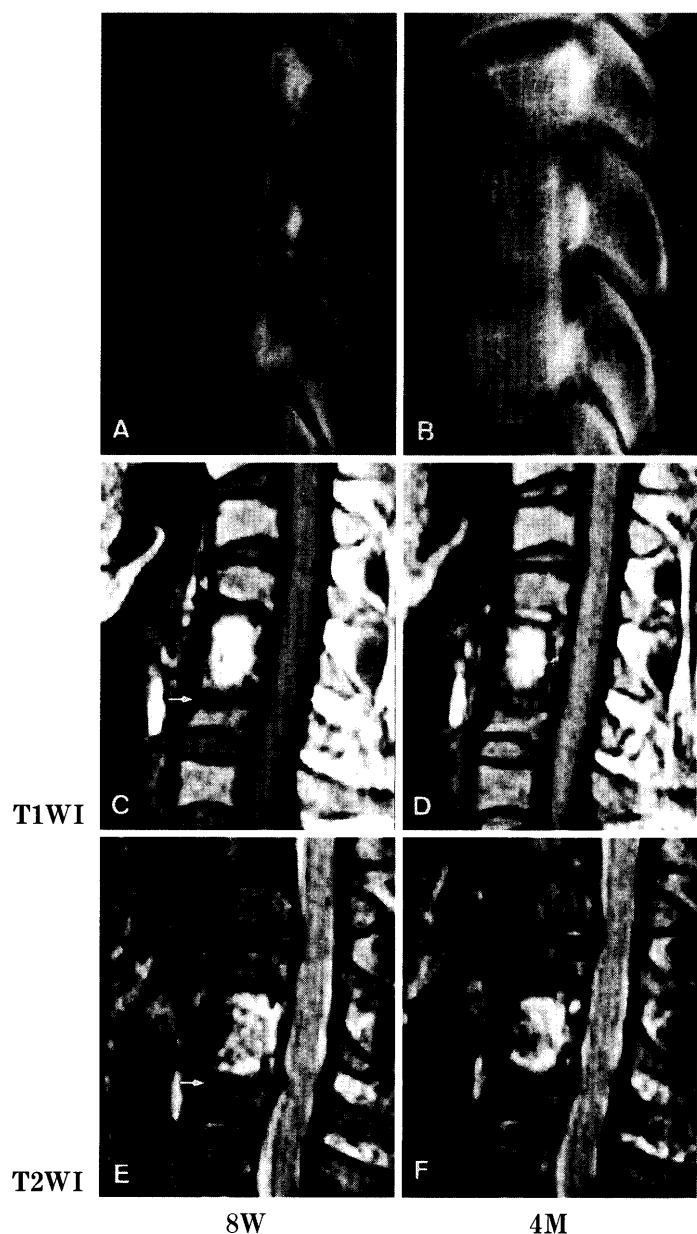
At eight weeks after surgery, a small collapse develops at the lower edge of the graft (A), and a transient widening of the border is observed on both T1-weighted and T2-weighted images (C and E), exhibiting a PU1 pattern. At five months, the border has disappeared with the completion of bony union (D and F).
